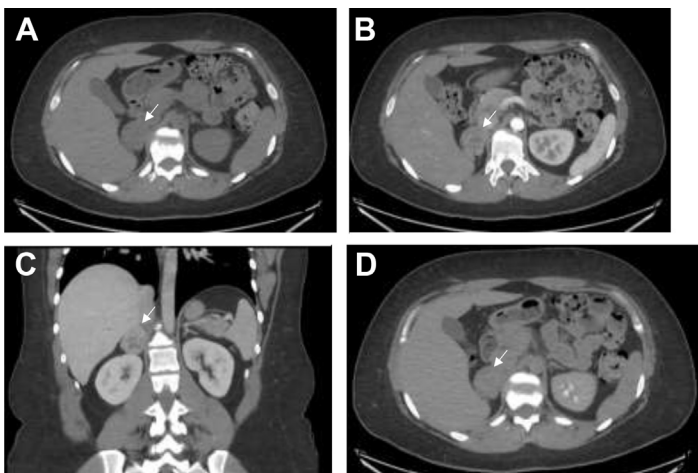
A 34-year-old woman presented to the endocrinology clinic with an incidental adrenal mass discovered on CT at an outside facility performed after a motor vehicle accident. She reported a history of hypertension and worsening anxiety over the past year. Axial unenhanced CT (A) demonstrates a well circumscribed oval mass measuring 4.2 cm in maximal dimension involving the right adrenal gland with a precontrast attenuation of 28 HU. Contrast enhanced CT in arterial phase (B) shows a heterogeneously enhancing mass with attenuation of 56 HU, in the context of increased plasma metanephrines, compatible with pheochromocytoma (arrow). Coronal reformatted image of CT in the venous phase (C) demonstrates attenuation of 91 HU in the mass. Delayed 15-minute axial CT (D) shows contrast washout with attenuation of 58 HU, yielding an absolute enhancement washout of 52%. This mass was surgically resected and pathologically proven to represent pheochromocytoma (arrows in A-D).
